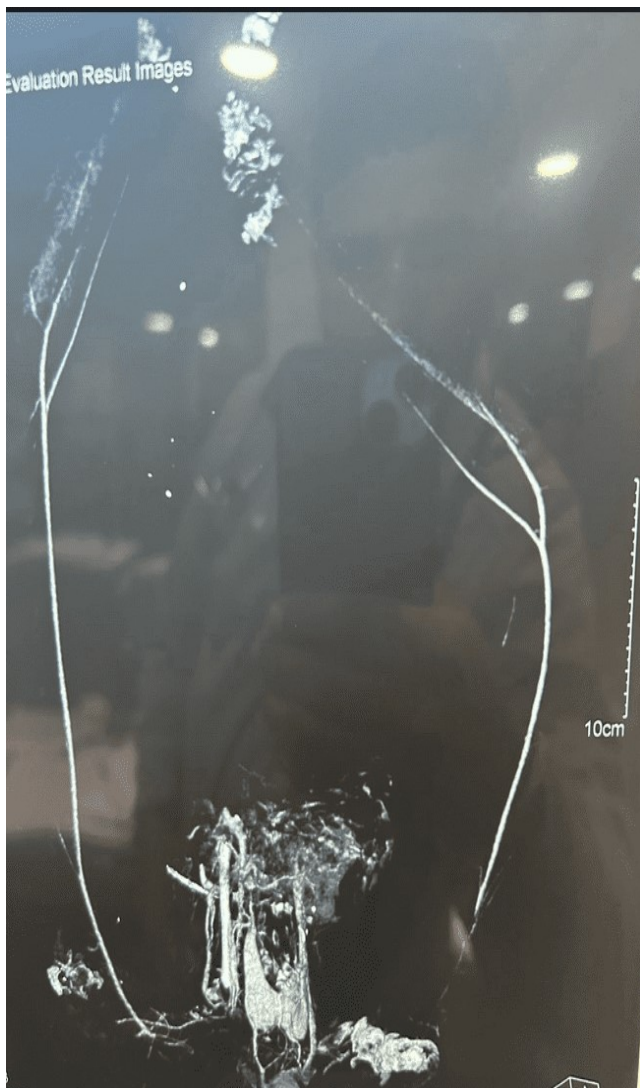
CT angio bilateral upper limb arterial system non opacification right brachiocephalic trunk and left common carotid till bifurcation
